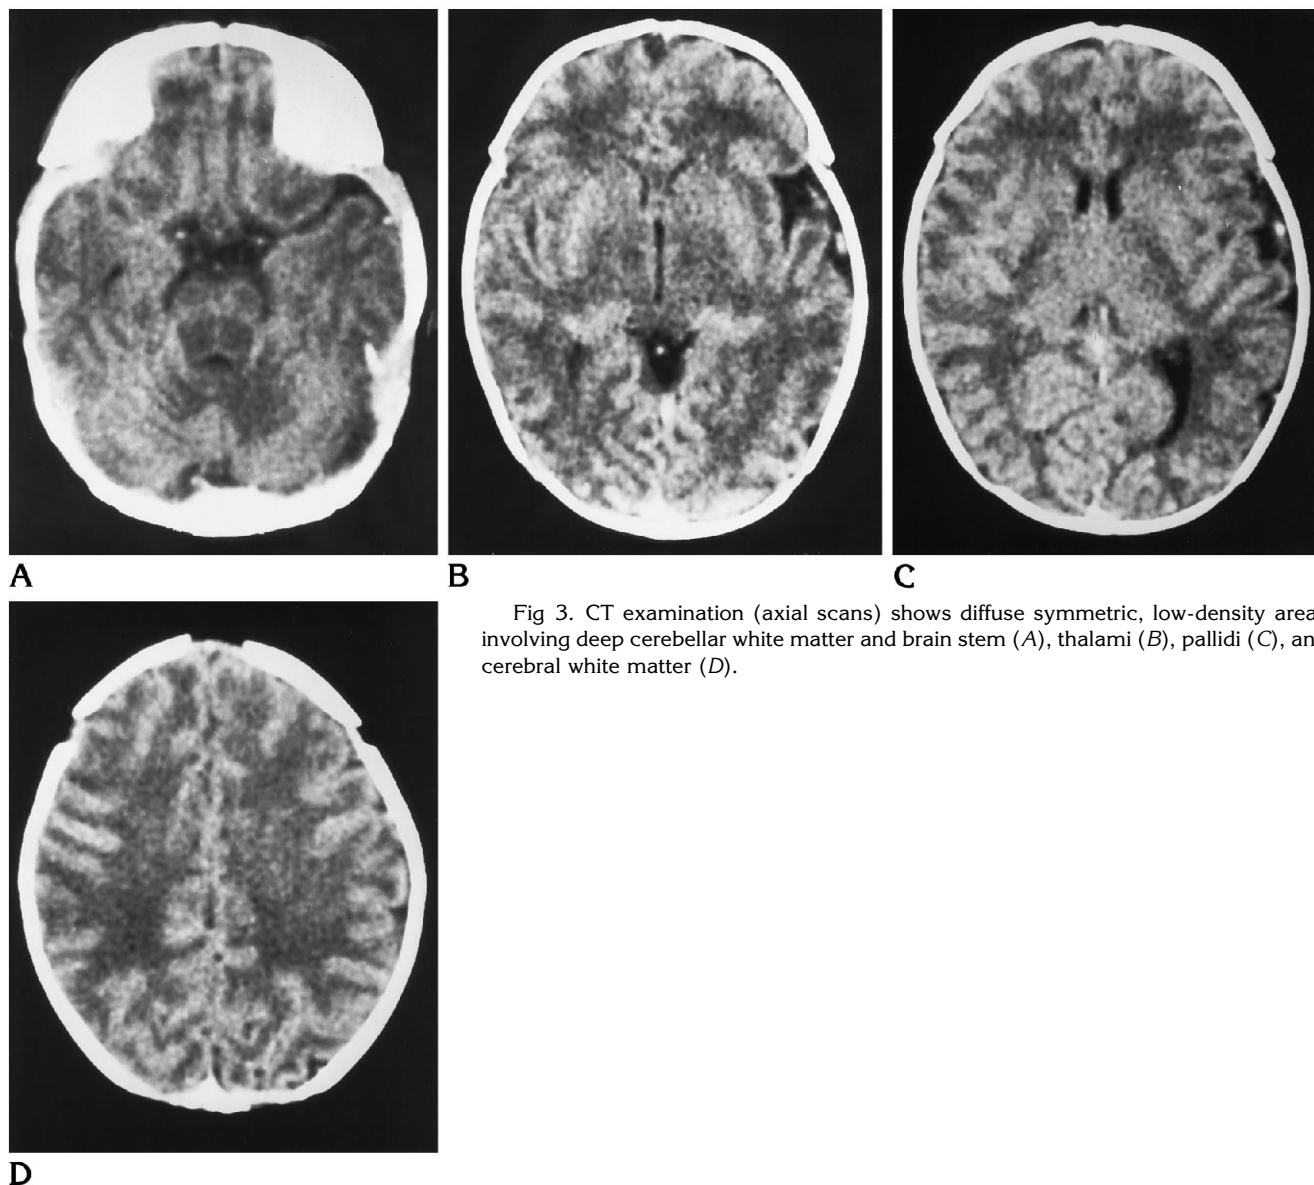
CT examination (axial scans) shows diffuse symmetric, low-density areas involving deep cerebellar white matter and brain stem (A), thalami (B), pallidi (C), and cerebral white matter (D).
